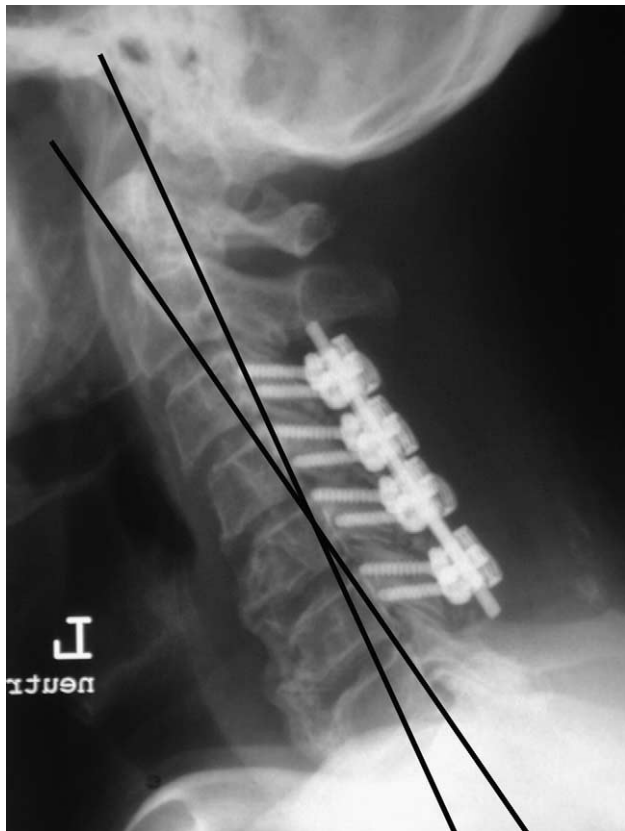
Typical postoperative neutral lateral c-spine X-ray showing how the C2/C7 sagittal balance angle was measured. Two lines parallel to the posterior vertebral body borders of C2 and C7 were made and their angle at intersection were calculated. If there was kyphosis, the angles were negative with lordosis giving positive angles.
